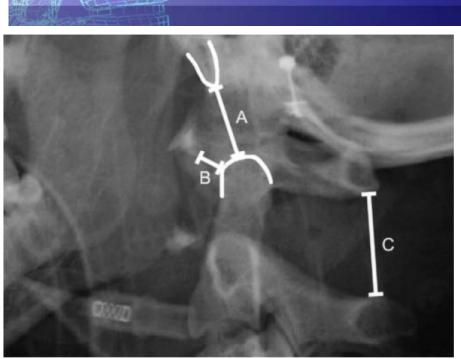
Cross-table lateral cervical radiograph revealing a vertical distraction injury in a patient who died soon after the radiographs were obtained. The C-1 ring and skull base are markedly displaced cephalad with respect to C-2. The BDI is widened (Line A), and the atlantodens distance is increased (Line B). The distance between the posterior elements of C-1 and C-2 is grossly increased (Line C).
